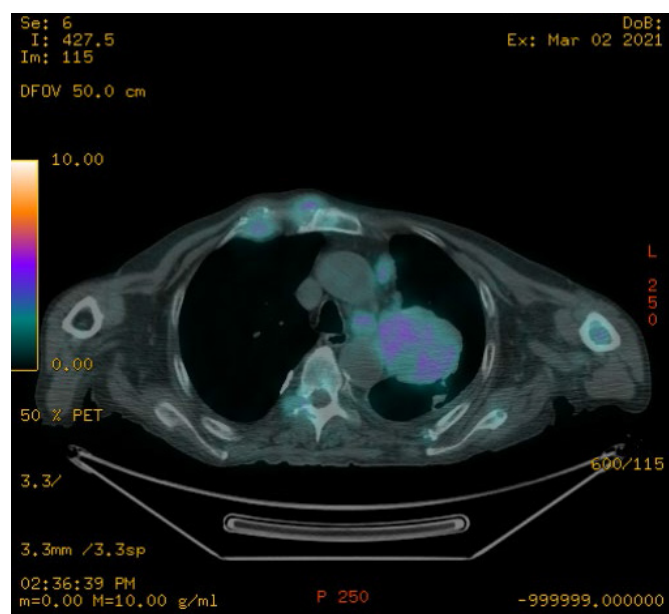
PET/CT cross-section
